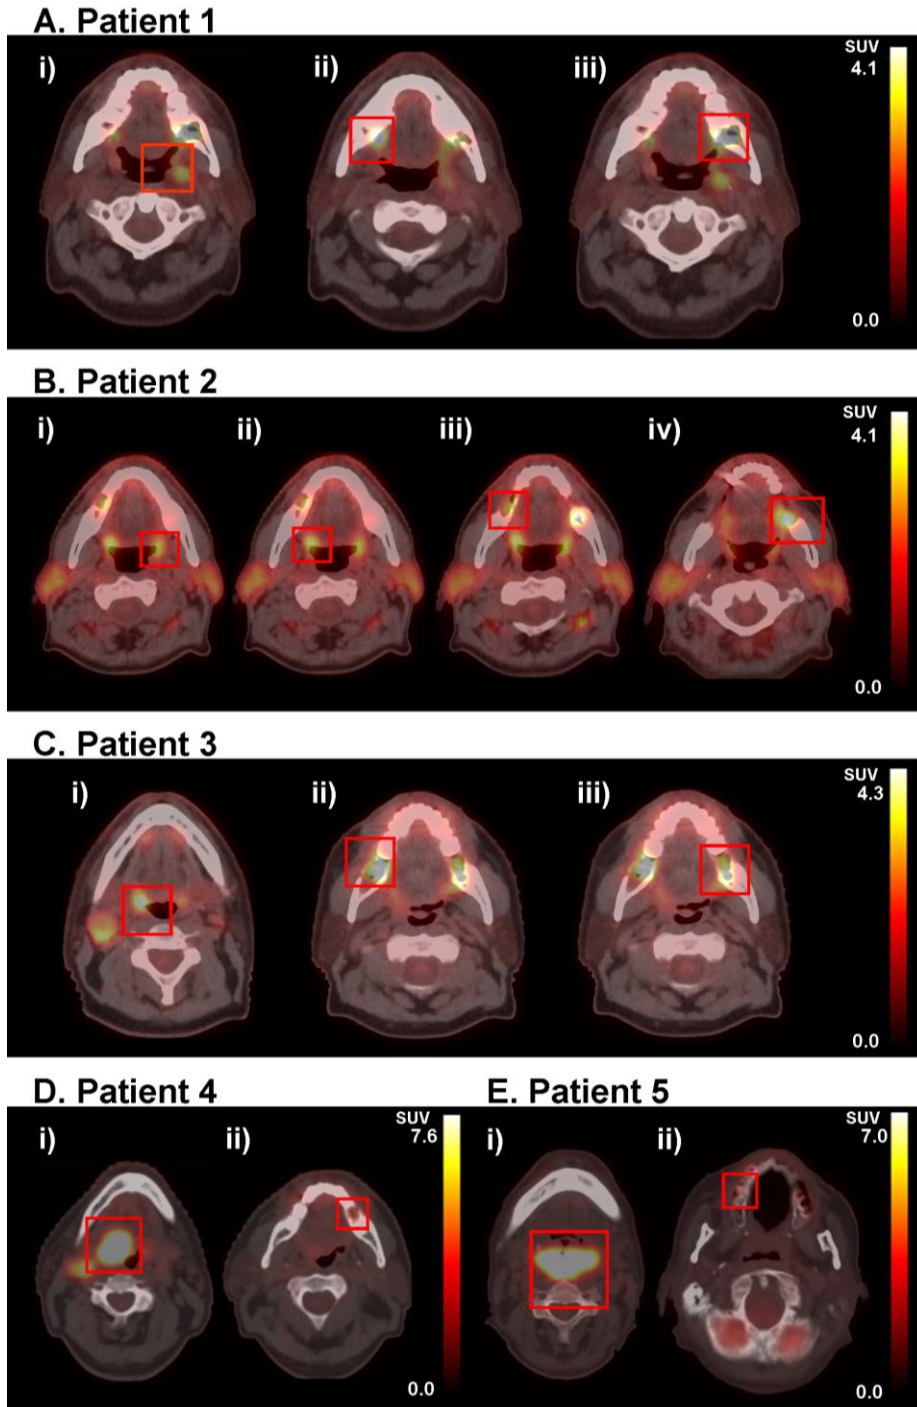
Fused PET-CT images of the patients showing anatomical location of the VOIs included in the study. A. Patient 1 images, red coloured bounding box encloses i) tumour located at palatine tonsil, ii) inflammation within right jaw at the site of dental extraction, iii) inflammation within left jaw at the site of dental extraction. B. Patient 2 images, red coloured bounding box encloses i) tumour located at palatine tonsil, ii)
